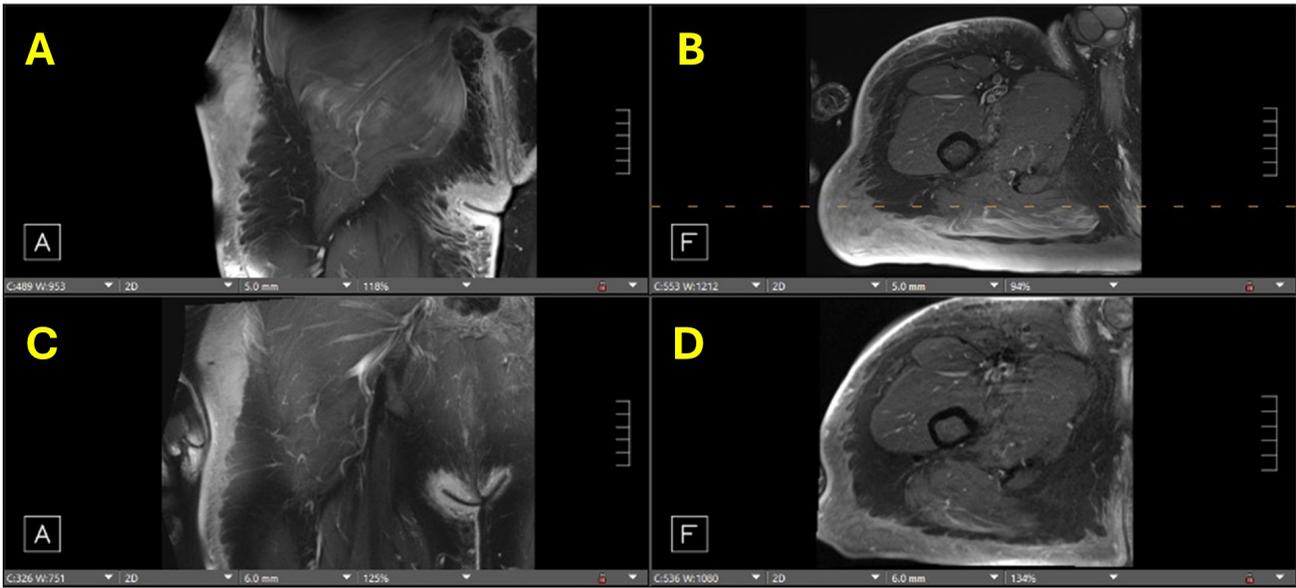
T1-weighted magnetic resonance imaging with contrast of the right femur. (A) Top left: coronal view (2024). (B) Top right: axial view (2024). (C) Bottom left: coronal view (2019). (D) Bottom right: axial view (2019).
